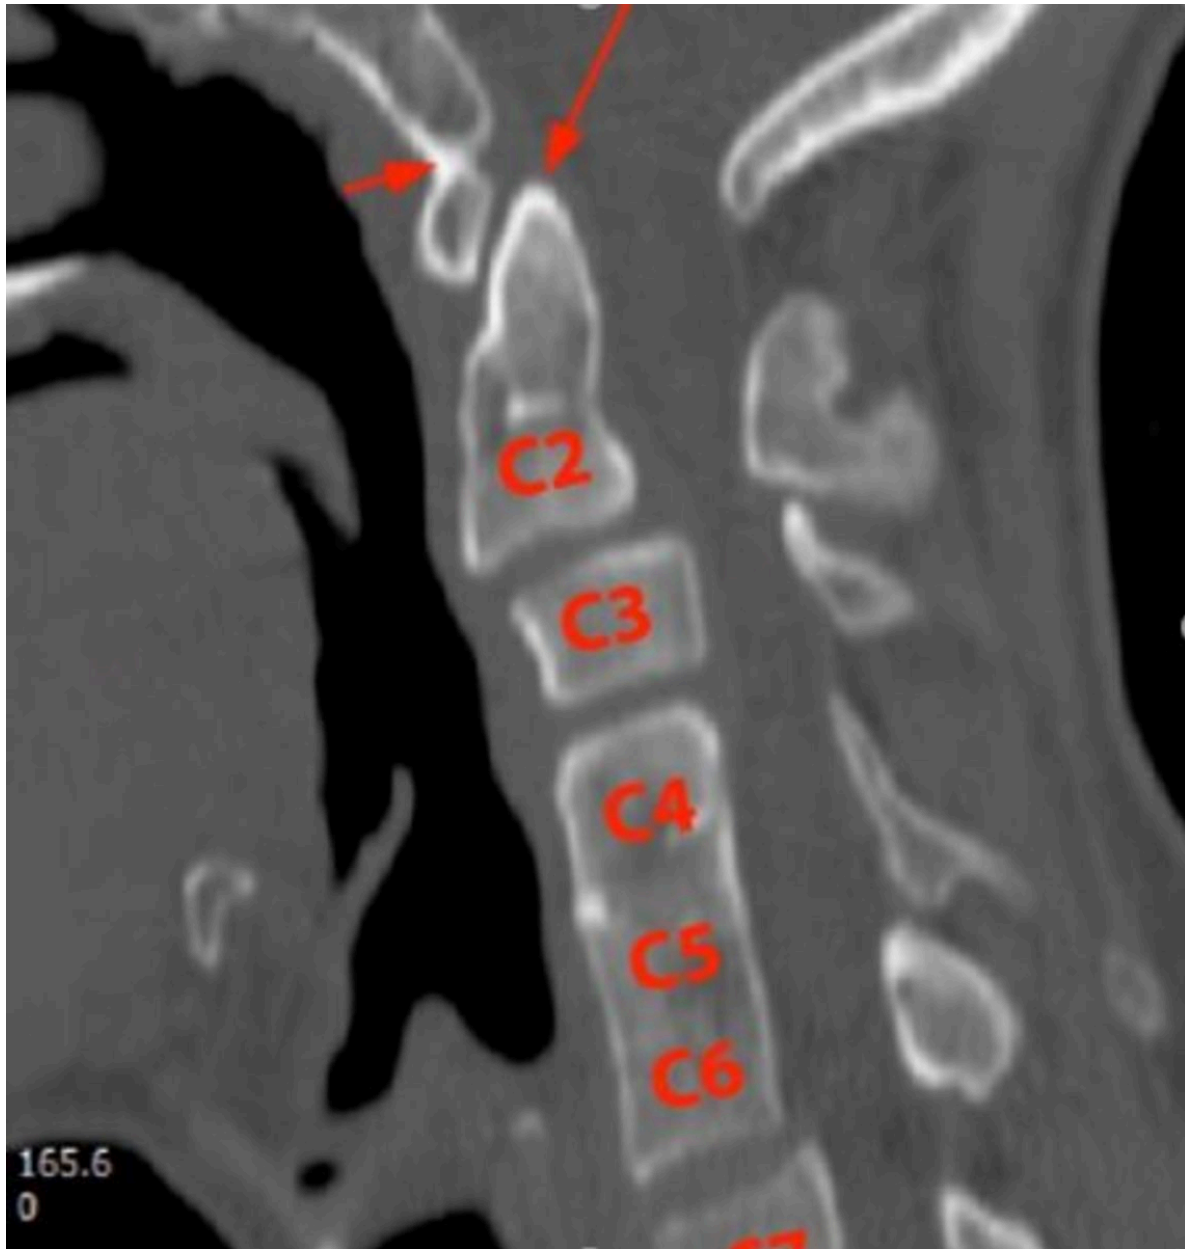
CT sagittal reconstructed image showing multilevel fusions with atlantooccipital assimilation (arrows), fused vertebrae from C4-C6.-representing type 1
